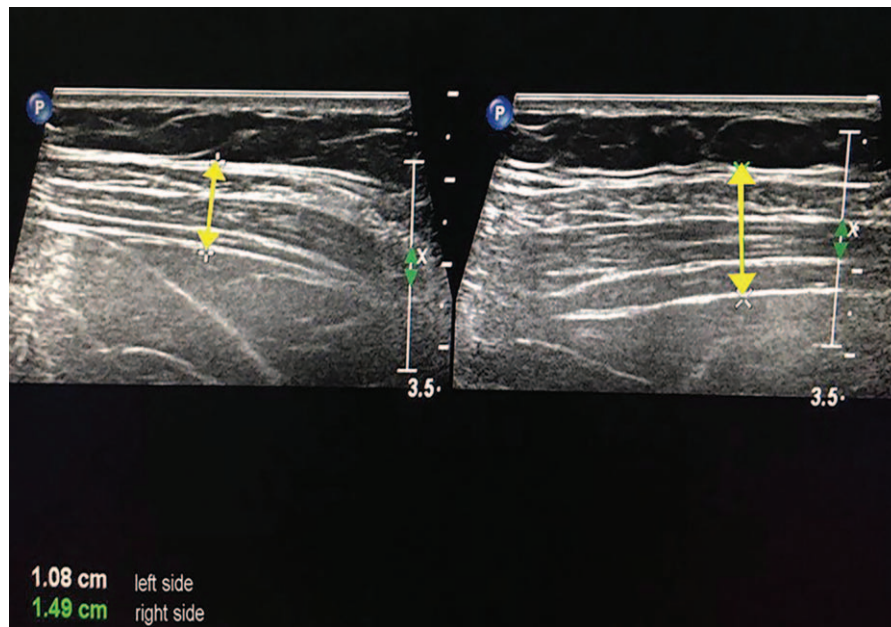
Preoperative color Doppler ultrasound: The image showed that the left anterolateral abdominal wall was thinner than the right anterolateral abdominal wall.
